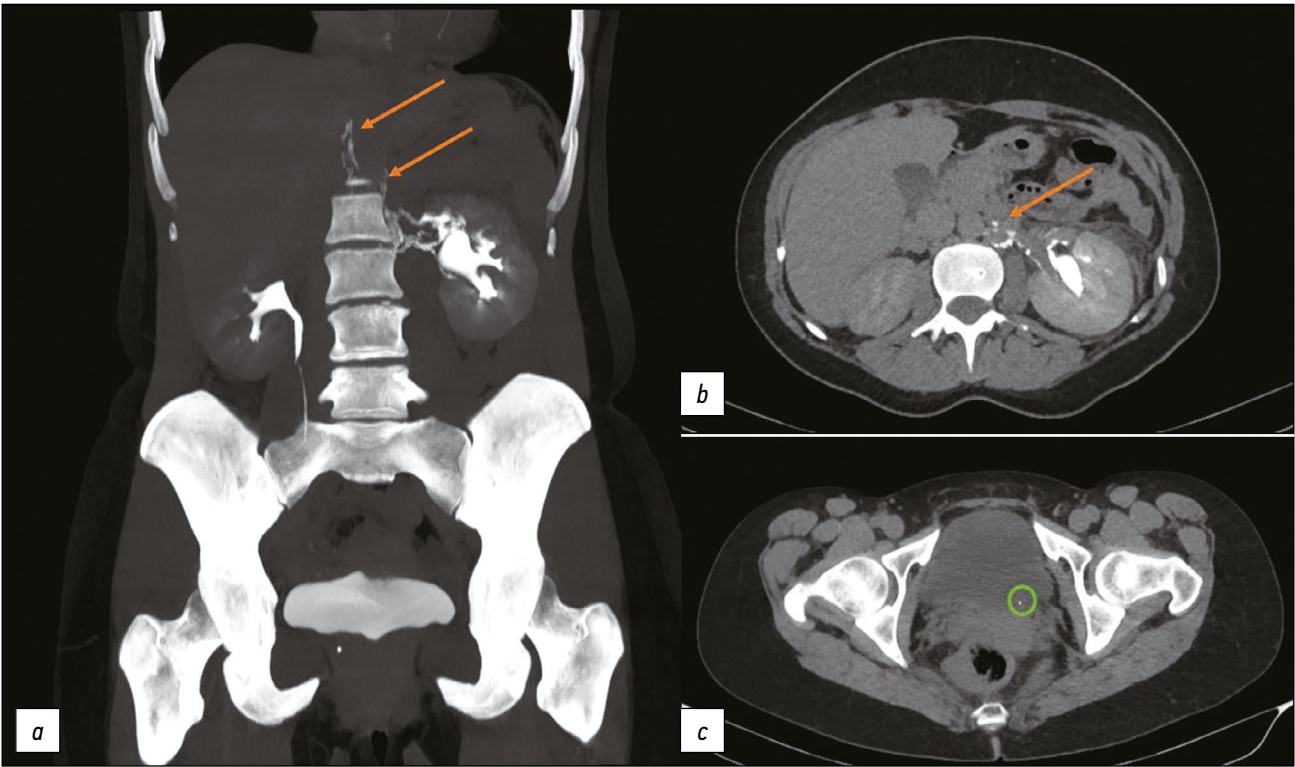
Computed tomography of the abdomen with intravenous contrast enhancement. The excretory phase: (a, b) Orange arrows show the contrast spreading along lymphatic vessels; (c) A green circle highlights a calculus at the left ureteric orifice.
